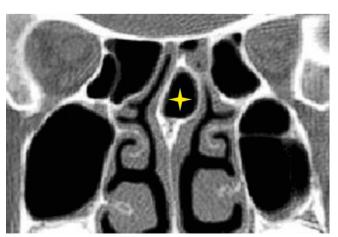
CT scan showing nasal septal bullosa (star).
